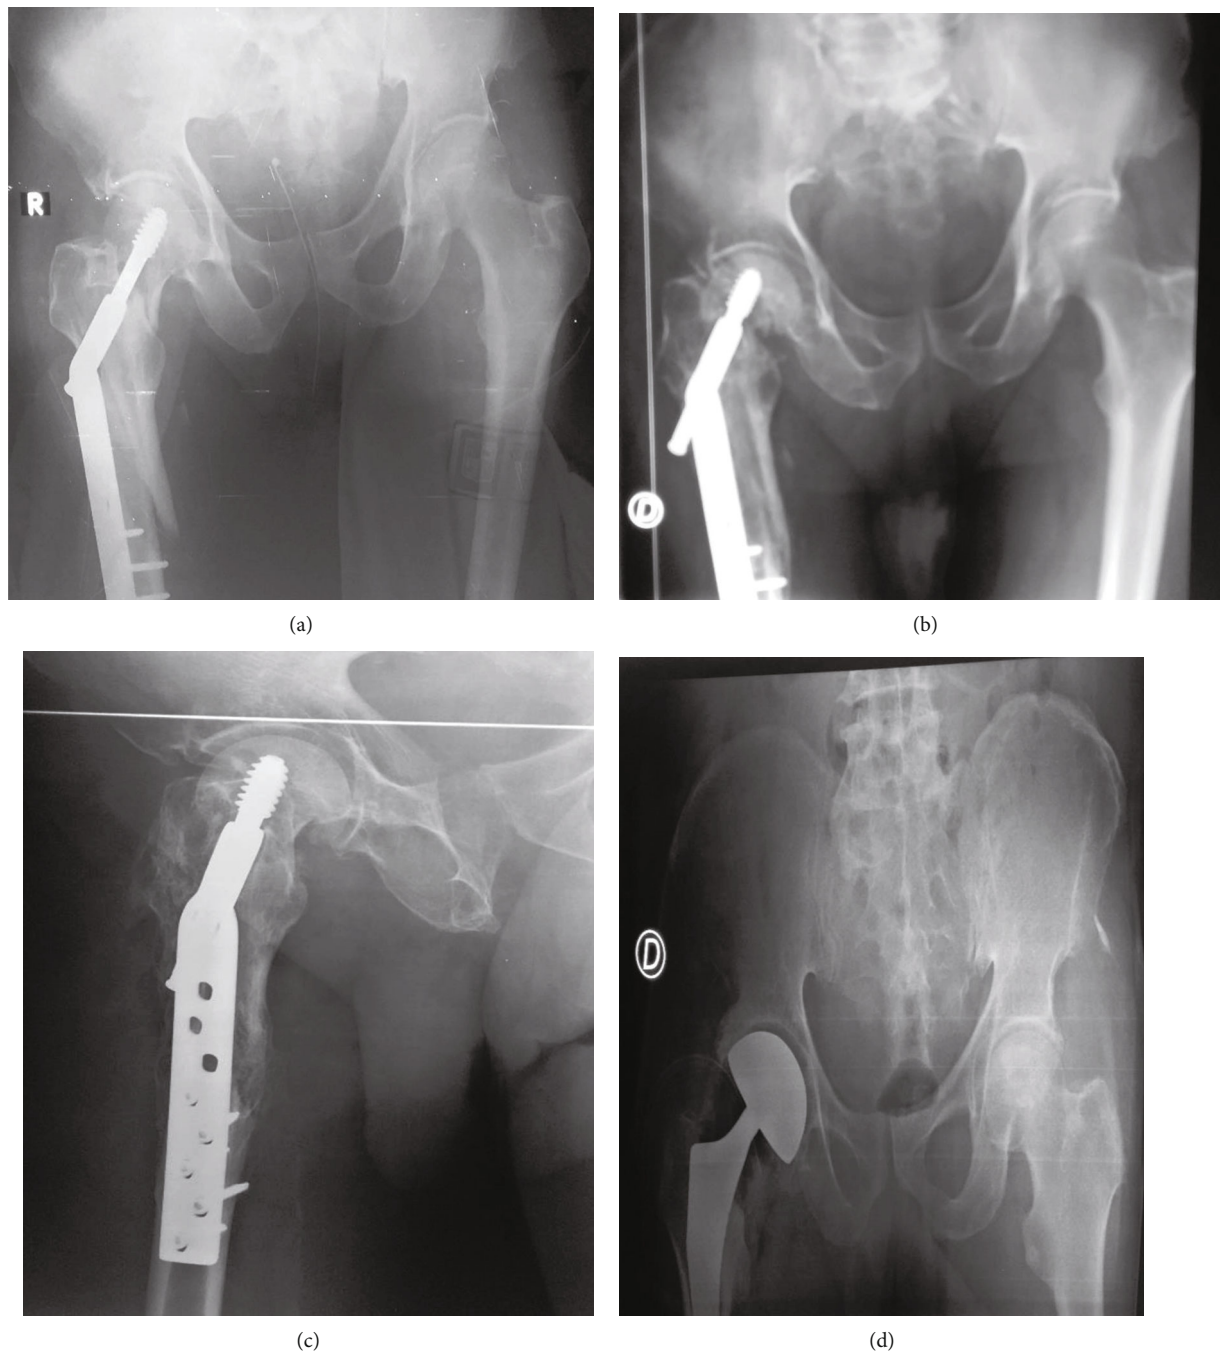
X-rays of patient 3. (a) Osteosynthesis y DHS. (b) Subtrochanteric malunion with pseudarthrosis of femur neck. (c) Cut out phenenon. (d) Hemiarthroplasty.
